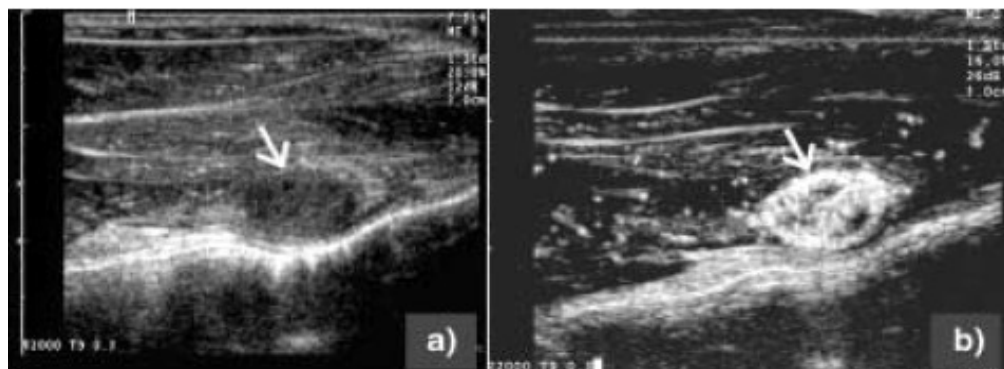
The image of microbubbles under ultrasound (Source: Schutt, Klein, Mattrey, & Riess, 2003)
